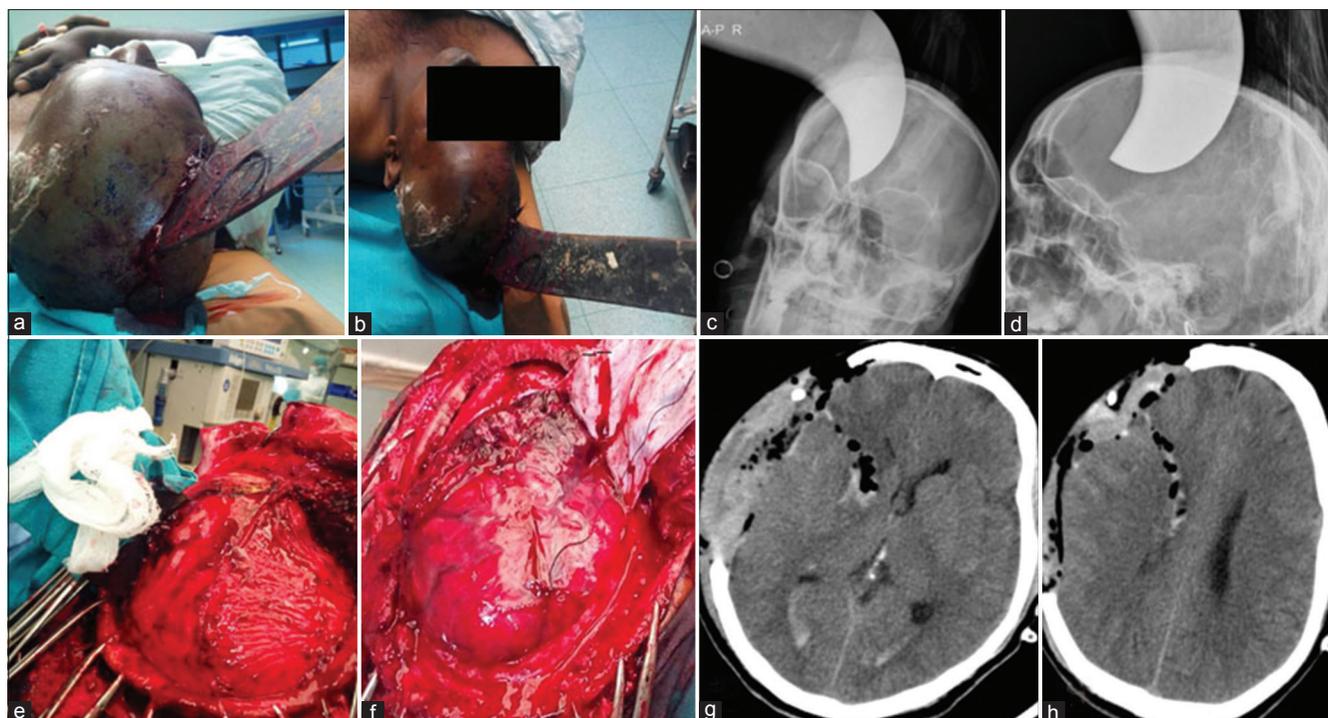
(a and b) Photograph showing penetrating injury by machete to right frontal region, with the weapon firmly stuck to calvarium. (c and d): X-ray skull AP and lateral oblique views showed the metal weapon penetrating the calvarial bone. (e and f): Operative photographs showing the machete stuck to frontal bone (e). After craniotomy and dural opening, underlying laceration of frontal lobe was noted (f). (g and h): CT head plain images axial sections showed air and specks of blood along the trajectory of the weapon in the right frontal lobe and caudate region, with blood in both occipital horns
